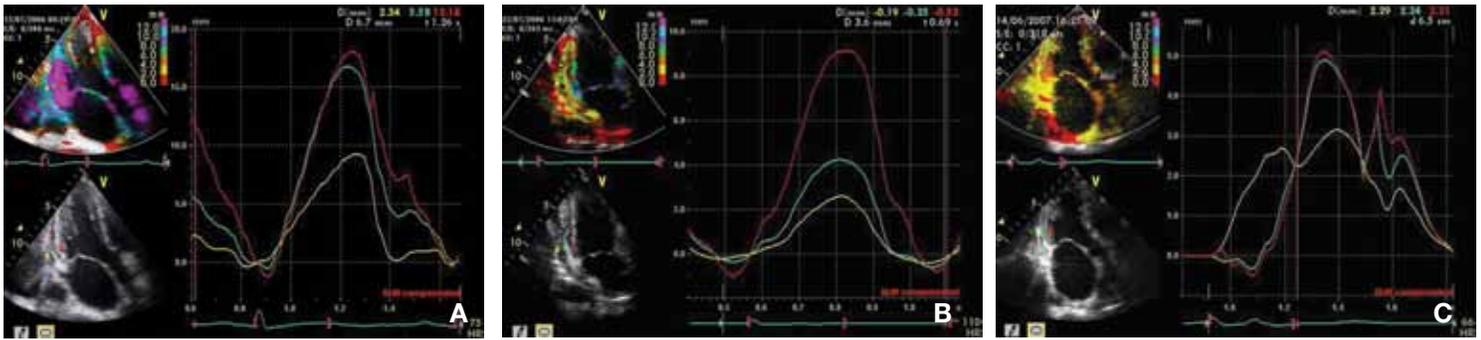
Quantitative tissue Doppler imaging in (A) a normal subject, (B) a patient with constrictive pericarditis, and (C) a patient with restrictive cardiomyopathy. Yellow line: parietal pericardium; blue line: outer-layer myocardium; red line: inner-layer myocardium (courtesy XF Wang). See text for discussion.
